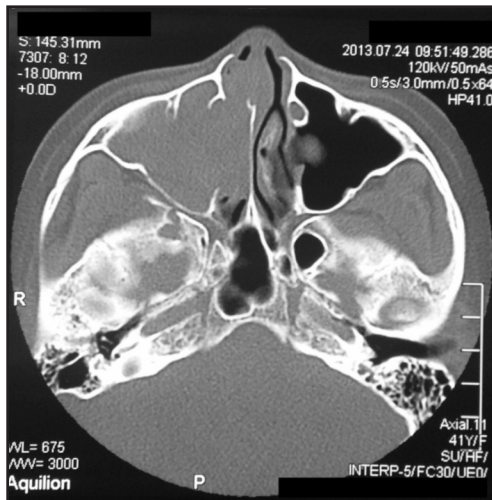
CT scan axial view homogenous mass at right nasal cavity and right maxillary sinus.
